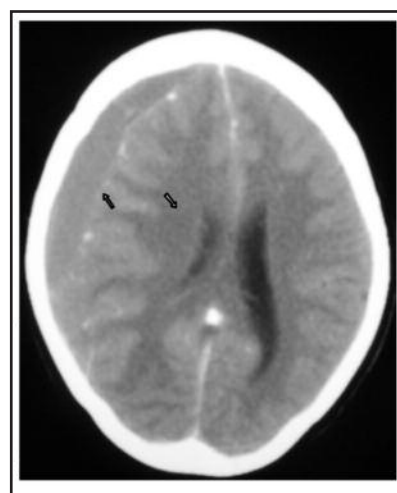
(Case 4): CT scan brain showing right fronto-parietal subdural haemorrhage with mass effect (midline shift).
